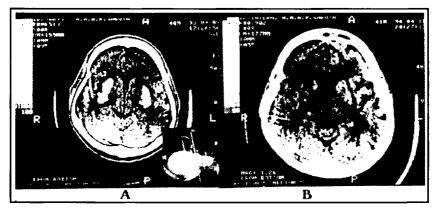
Computed tomography (CT) scans of the head: A - at seven days after admission. B - at six months. See text for description of CT findings.
